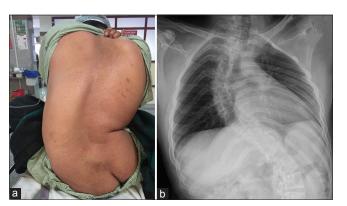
(a) Patient Spine, (b) X-ray spine
